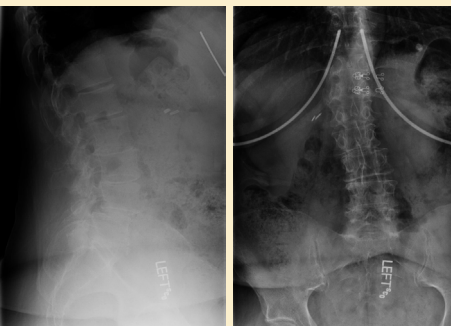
Pre op lateral and A/P x-rays demonstrating degenerative spondylolisthesis at L4-5 and significant degenerative disc disease at L2-3, L3-4, and L4-5.
